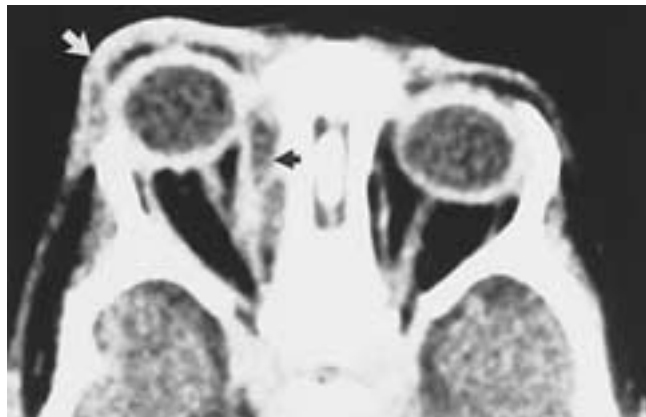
Preseptal and retroseptal orbital inflammation. Axial CT scan shows periorbital soft-tissue infiltration and edema (white arrow) and retroseptal subperiosteal inflammation and edema (black arrow).
